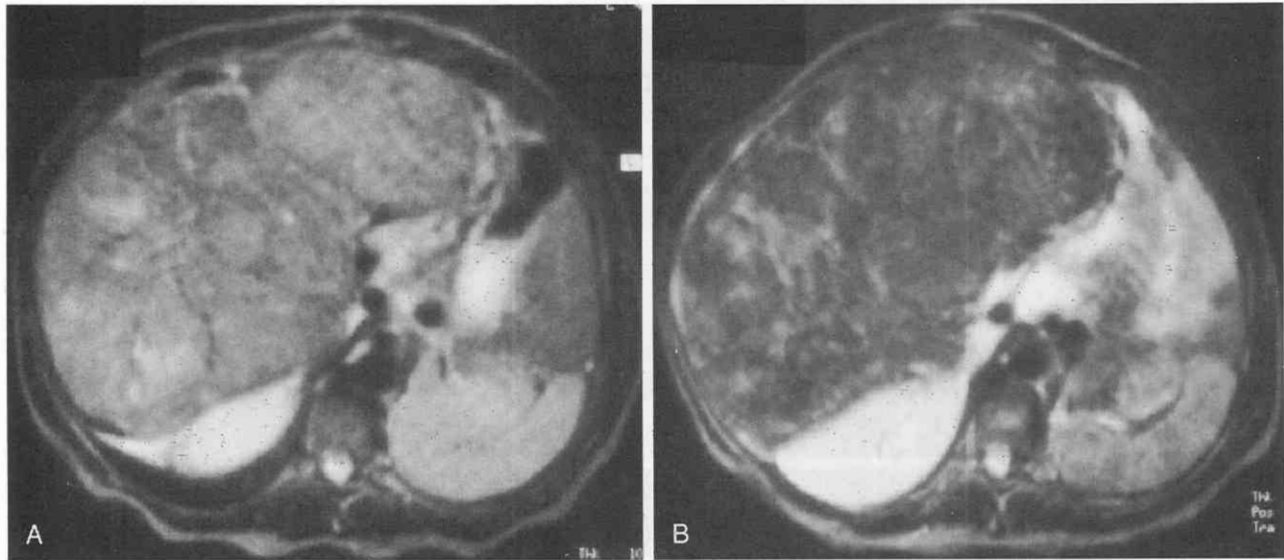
Hepatocellular adenoma. A, Unenhanced T2-weighted image demonstrates a very large hepatic lesion. B, T2-weighted image after superparamagnetic iron oxide (SPIO) enhancement demonstrates signal loss from the lesion.
